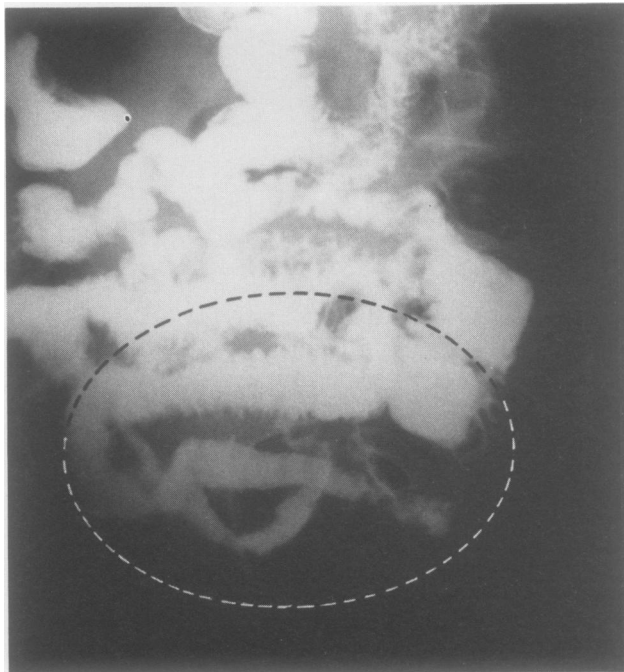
Small bowel contrast roentgenogram in patient 22, with known portomesenteric venous thrombosis and persistent postprandial pain and anorexia. Note edema, spicules, "thumbprinting," and poor distensibility of distal ileum.
